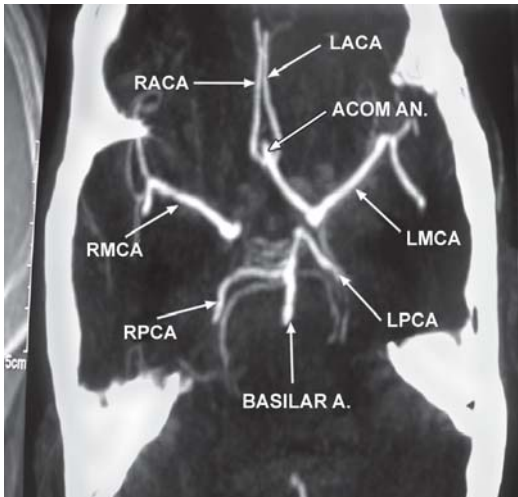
CT angiography showing aneurysm of anterior communicating artery
